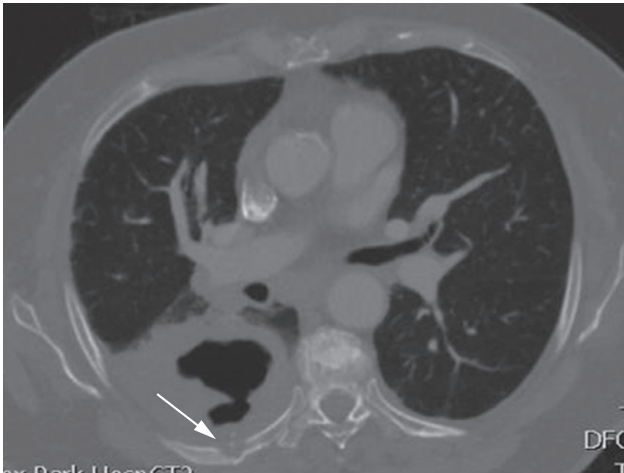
CT showing a cavitating lung cancer with local invasion of the chest wall and erosion of the cortex of the adjacent rib (arrow).
